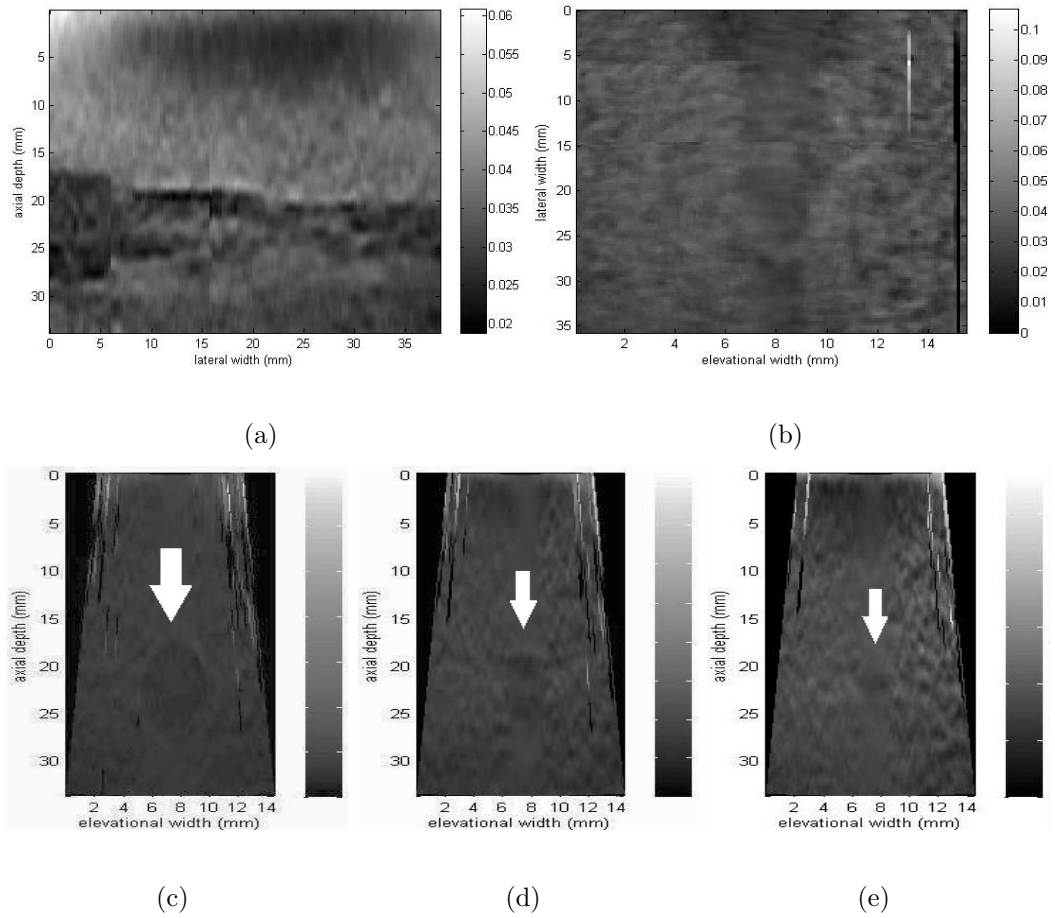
3D ultrasound elastography mosaic: axial-lateral plane (a), lateral-elevational plane (b), and 3 axial-elevational planes through 3 different diameters of the stepped cylinder (c, d, e)
